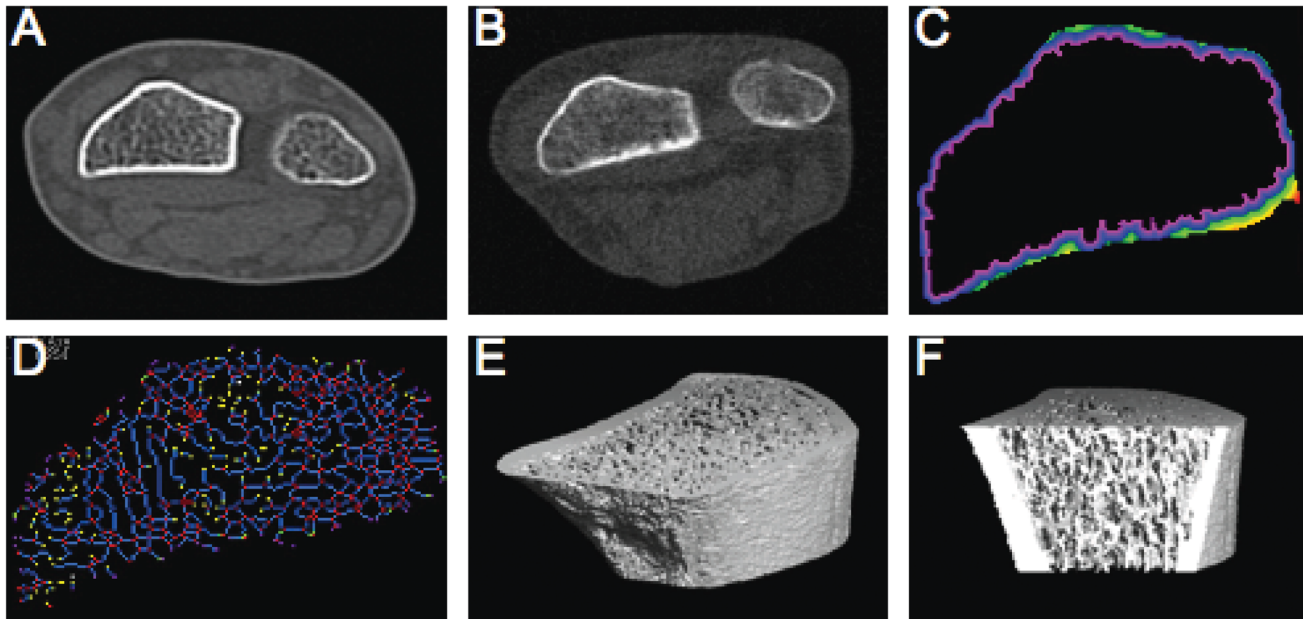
Examples of distal radius images: Cross-sectional image of radius and ulna using whole-body CT (Aquilion CX, Toshiba) (A); improved resolution using pQCT (XCT 960, Stratec) (B); analysis of (B) using OsteoQ software to facilitate analysis of cortical shell thickness (C) and trabecular connectivity (D); ultradistal radius imaged by HR-pQCT (Xtreme, Scanco) (E); and (E) sectioned for analysis of the trabecular network (F)
